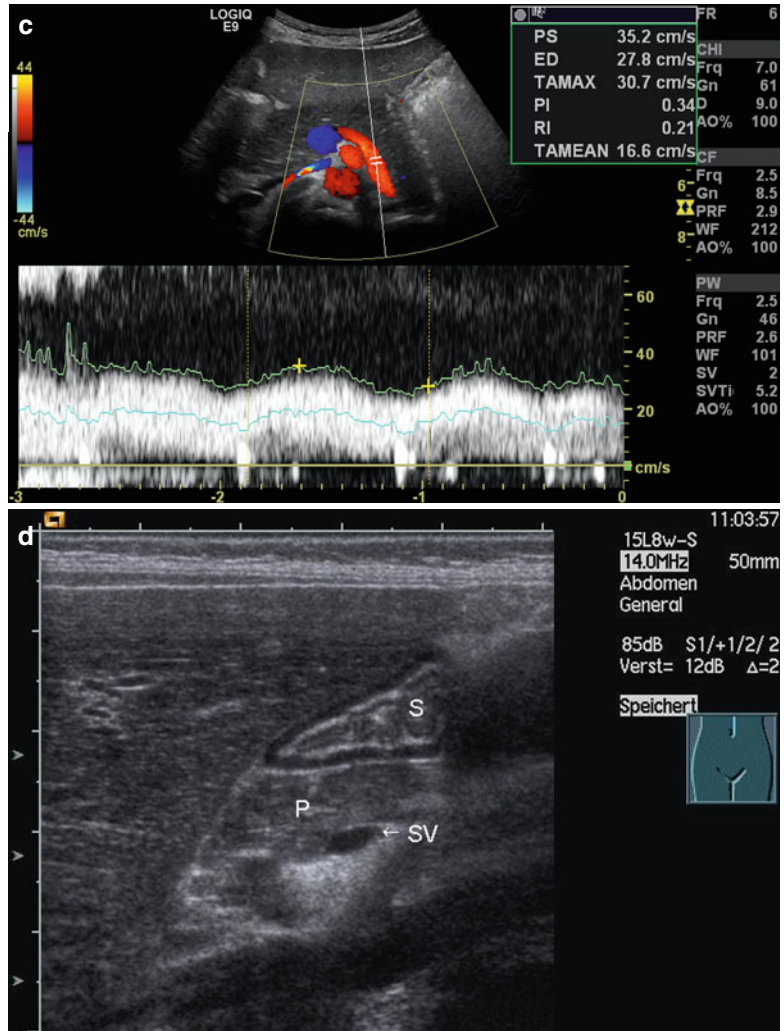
(a) The splenic vein can be imaged behind the body and tail of the pancreas in B-mode. Transverse section through the upper abdomen. (b) Colour Doppler of the flow in the splenic vein in a transverse section through the upper abdomen. The flow in the splenic vein (SV) along the pancreatic tail is directed towards the transducer and therefore displayed red. Close to the pancreatic head, the flow in the splenoportal confluence (SPC) is directed away from the transducer and therefore displayed blue. The aorta
